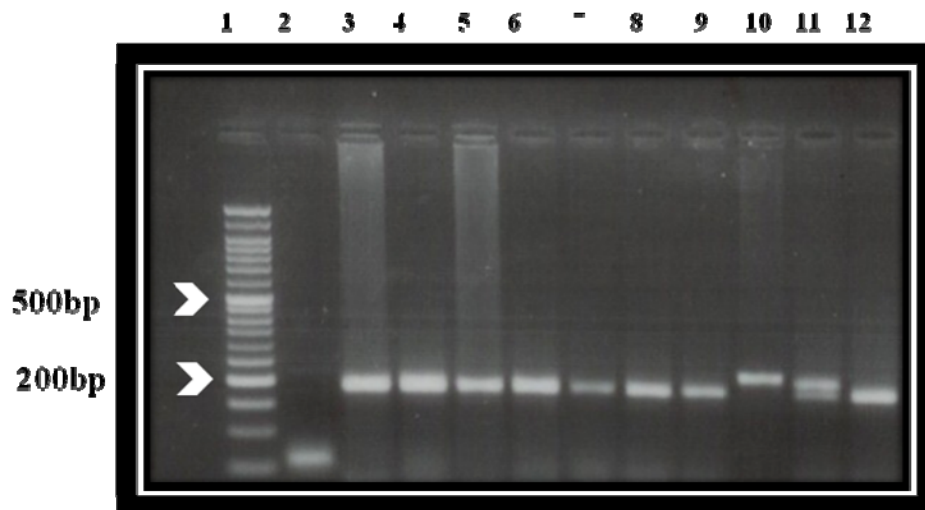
1426 C/T SNP genotyping by RFLP with *BstNI* enzyme. Lane 1 represents the 50 bp DNA ladder; Lane 2 is the negative control, lanes (3-9,12) show CC genotype with 183 bp band, and lane (10) shows the uncut products with 223bp band , lane (11) shows CT genotype with 208/183 bp bands size.
